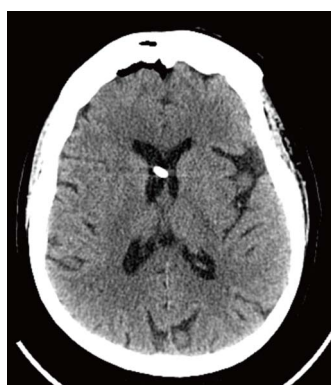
Intraoperative computed tomography of the head demonstrates intraventricular placement of the pump catheter (Patient 6).
